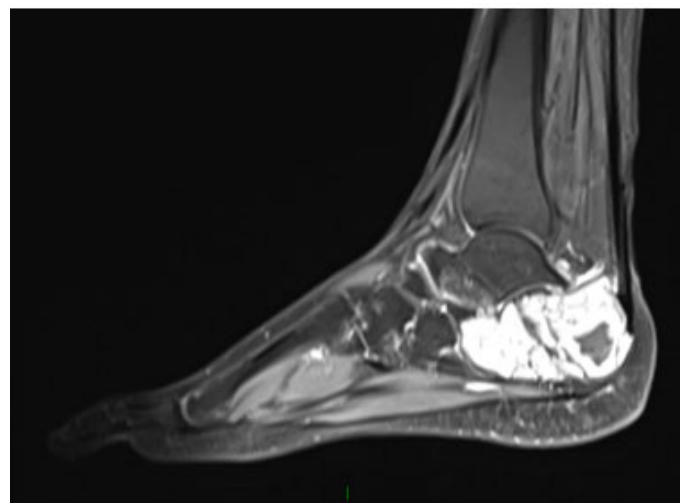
The magnetic resonance imaging (MRI) of the right foot with contrast revealed a large, heterogeneous, avidly enhancing lesion of the right calcaneum.
